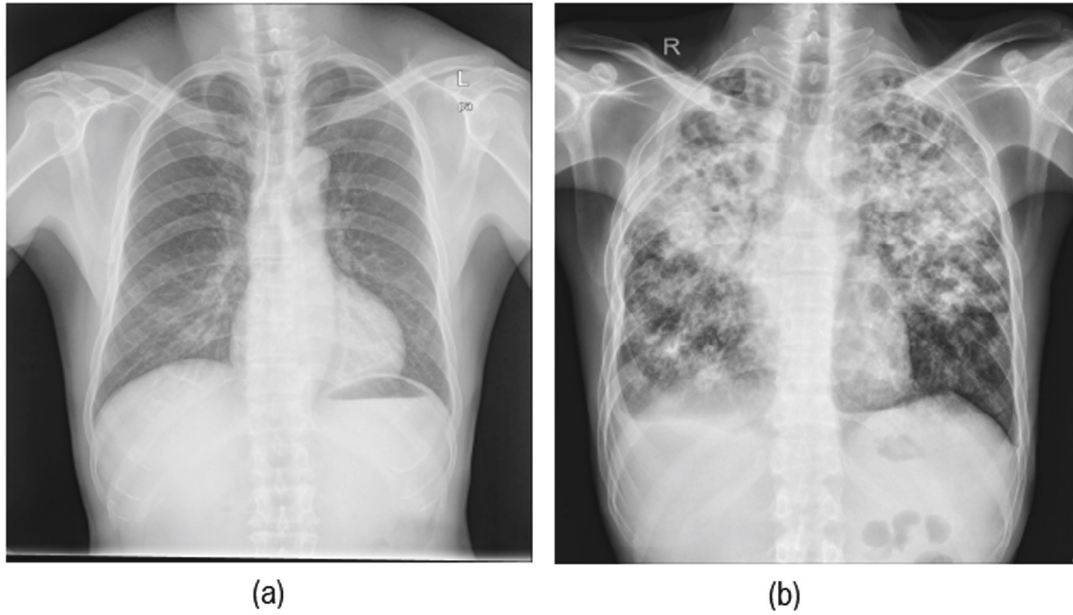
Sample in the Shenzhen Database. (a) is a healthy chest radiograph of a 60 years old male patient while (b) is an unhealthy chest radiograph of a 36 years old male patient diagnosed with “bilateral pulmonary TB”.
